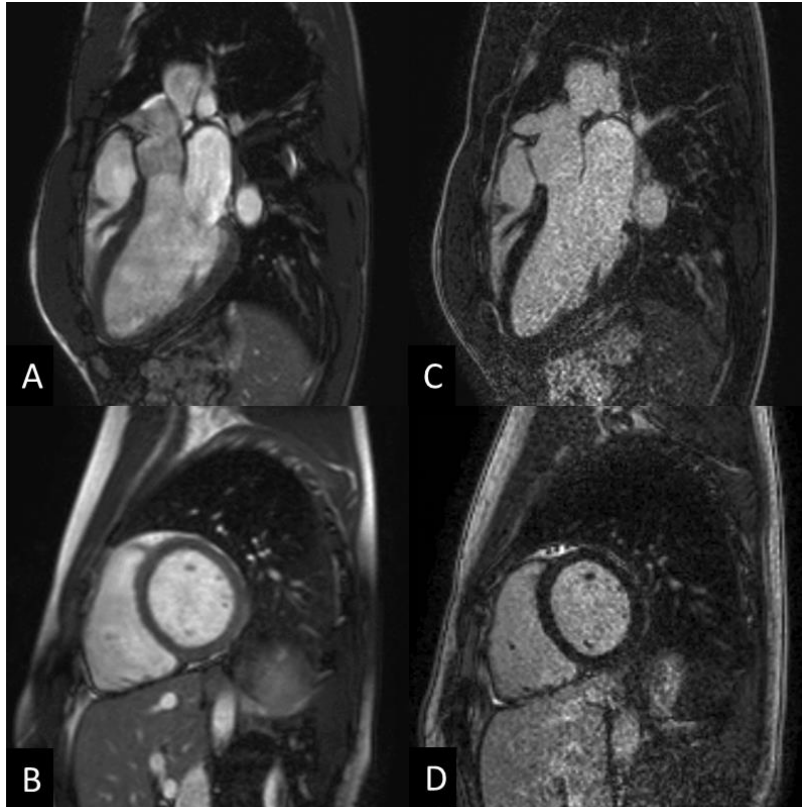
Cardiac magnetic resonance images of an athlete: cine balanced steady-state free precession (bSSFP) images (A,B) and late gadolinium enhancement images (C, D) in long- and short-axis views. Heart and Vascular Center, Semmelweis University.
